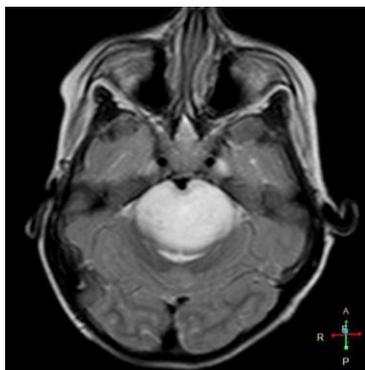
Axial T₁-weighted post-contrast MRI demonstrating mild patchy enhancement within a brainstem glioma. *Image obtained from Radiopaedia.org (CC BY-NC-ND 4.0).*
